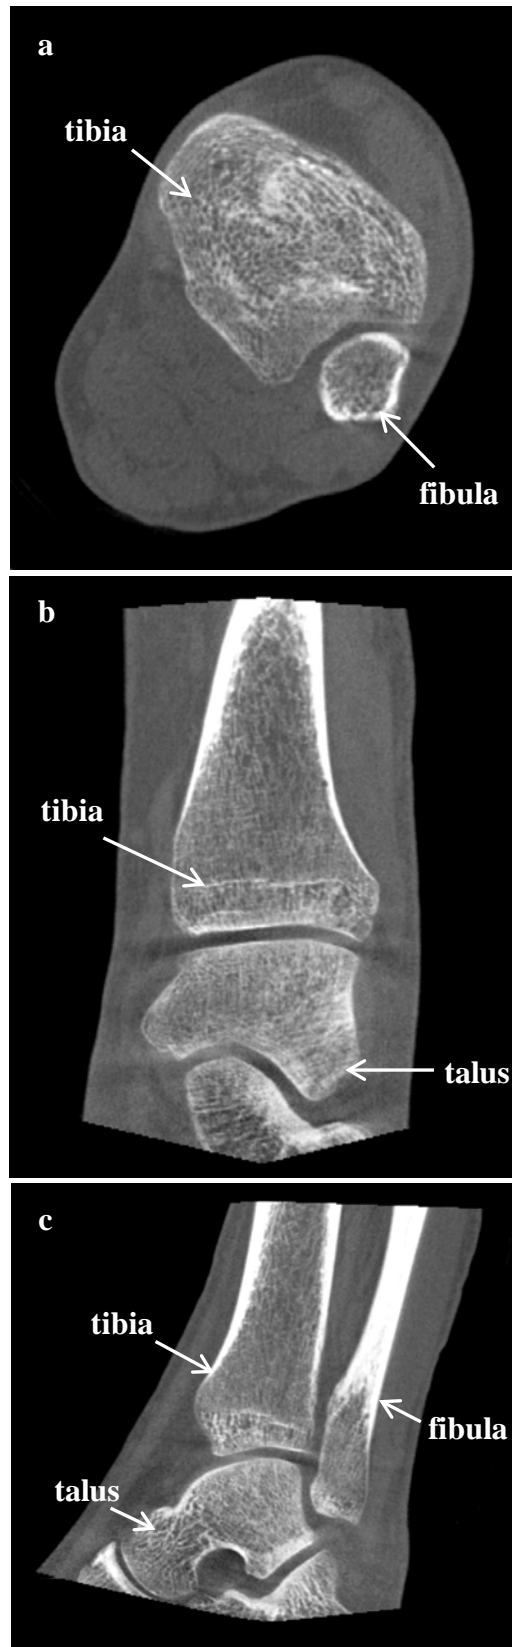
Computed tomography image of the patient's ankle. (a) Axial view. (b) Coronal view. (c) Sagittal view.
